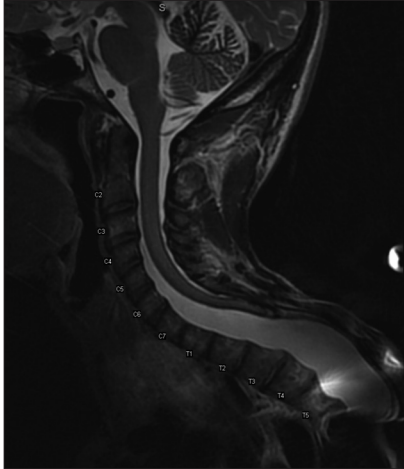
A T2-weighted sagittal magnetic resonance imaging of cervical and upper thoracic spine demonstrating dural ectasia in the upper thoracic spine associated with an apparent extensive laminectomy defect that begins at T2 and extends distally. The visualized thoracic spinal cord is markedly atretic and adherent to the posterior aspect of the thecal sac. There is considerable artifact from instrumentation at T6.
